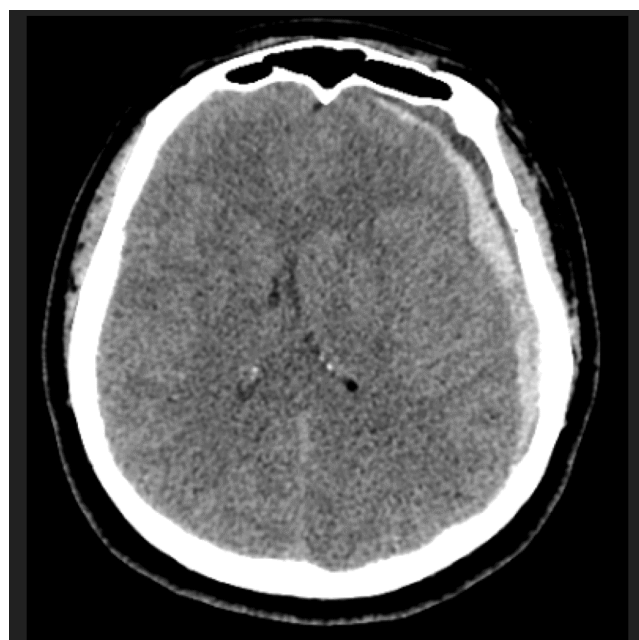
Post-operative brain CT scan revealed an acute left fronto-temporo-parietal subdural hematoma with 13 mm thickness and 10mm subfalcine herniation.
